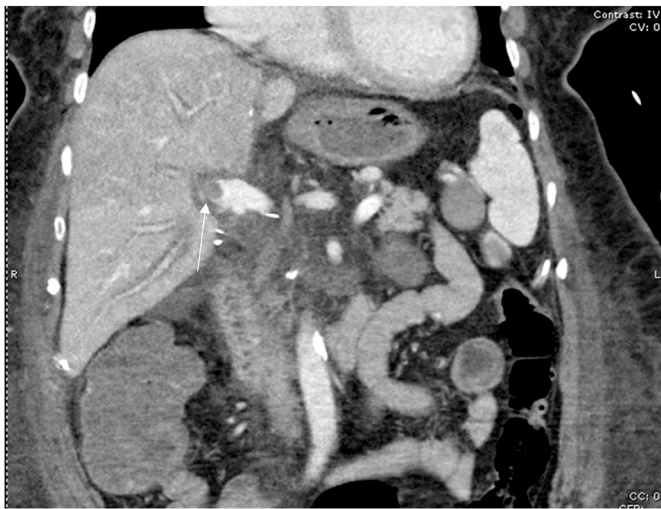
CT venous phase demonstrating thrombus (white arrow) of the distal MPV.
